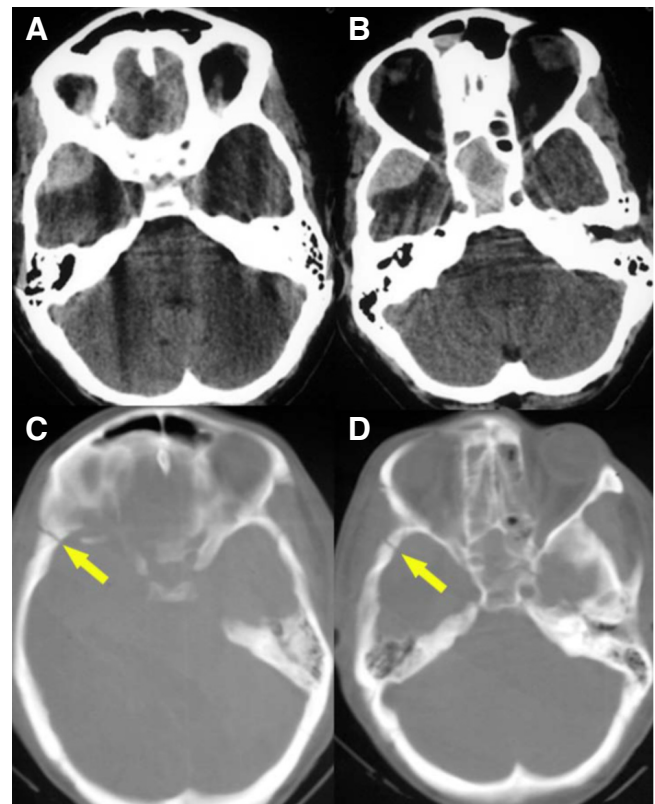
A & B. Non-contrast head CT, showing right temporal epidural hemorrhage. C & D. Bone window showing fracture of the right temporal bone.
